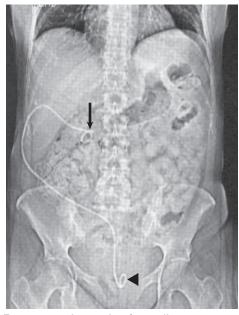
Extraanatomic stenting for malignant ureteral obstruction. Plain radiograph showing placement of an extraanatomic stent for malignant obstruction of the right ureter. The upper end of the double-J stent has been placed in the right renal pelvis (arrow). The stent then runs through a subcutaneous tunnel before the lower end enters the bladder (arrowhead).
